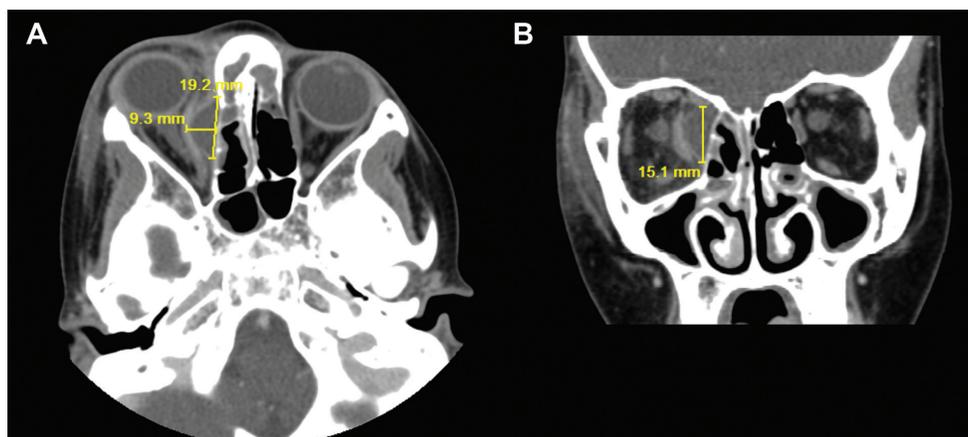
Computed tomography, sinus with contrast. Rim-enhancing subperiosteal abscess of 15.1 mm × 19.2 mm × 9.3 mm (volume of 2696 mm³) in the medial position. (A) Axial. (B) Coronal.
